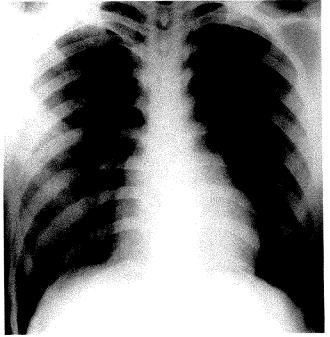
Chest radiograph 4 days after onset of symptoms shows large confluent areas of consolidation in both lungs. Note right lung and peripheral predominance of abnormalities.
